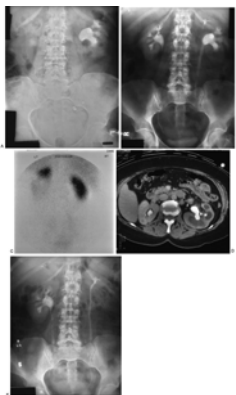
A: Plain film in this patient with recurrent urease-producing infection reveals a fully branched staghorn calculus overlying the left kidney. B: Intravenous urogram suggests contrast excretion from the lower pole, although this is a partially duplicated system, and function in that portion of the kidney was not proven on this study. C: Nuclear renogram reveals function only in the upper portion of the collecting system on the left side. The contrast in the lower pole on the left seen on the intravenous pyelogram was due to a “yo-yo effect” in the partially duplicated ureters. D: Computed tomography scan reveals thinning of the parenchyma in the involved lower portion of the collecting system. E: Following lower-pole partial nephrectomy, a well-functioning upper-pole system remains, as seen on this postoperative pyelogram.
